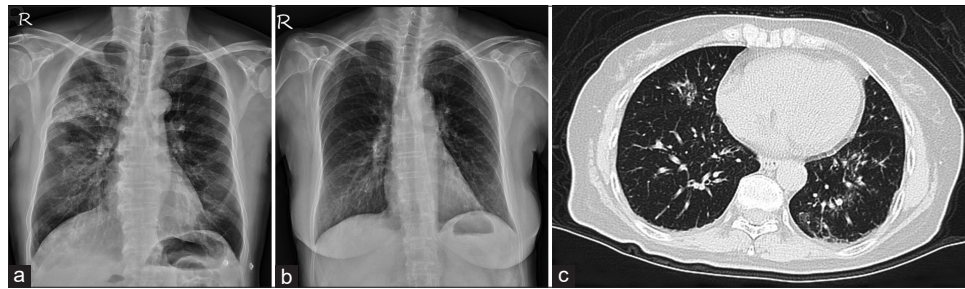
(a) The chest film showed increased interstitial infiltrations, patchy, and ground-glass opacity in the right upper lung field. (b) The chest film showed increased interstitial infiltrations in the bilateral lung fields. (c) Computed tomography of the chest revealed multiple ill-defined patchy ground-glass opacities and mild bronchial wall thickening with minimal centrilobular opacities in the bilateral lung fields
